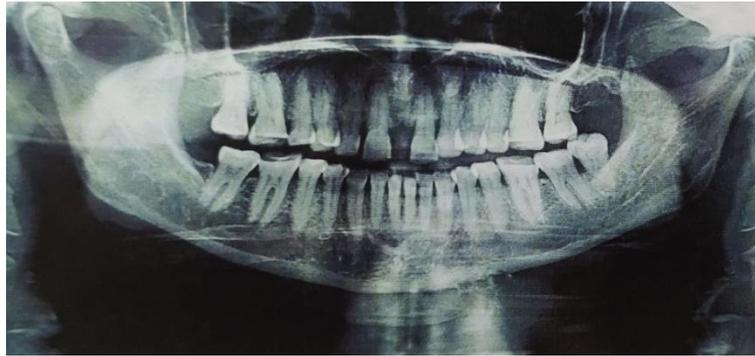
Panoramic radiograph showing ill defined multilocular radiolucent lesion on anterior border of mandible extending below inferior cortex
